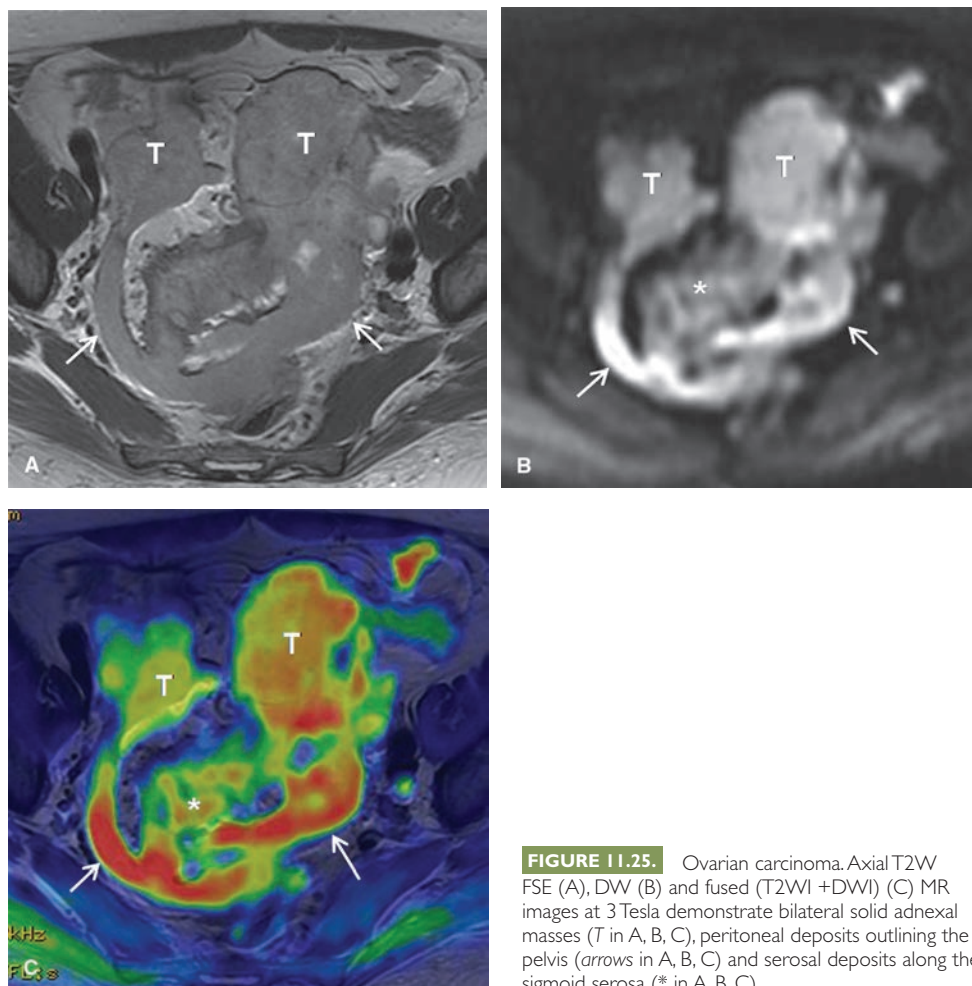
Ovarian carcinoma. Axial T2W FSE (A), DW (B) and fused (T2WI + DWI) (C) MR images at 3 Tesla demonstrate bilateral solid adnexal masses (T in A, B, C), peritoneal deposits outlining the pelvis (arrows in A, B, C) and serosal deposits along the sigmoid serosa (* in A, B, C).
